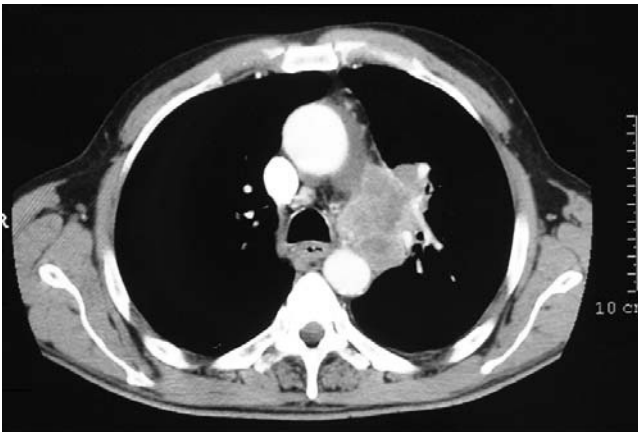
Computed tomography scan of the thorax, where a left hilar mass with signs of infiltration are observed.
